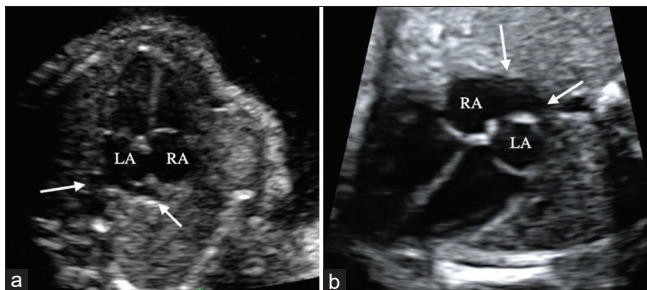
Two-dimensional gray-scale ultrasound of four-chamber view in a typical fetal heart versus right atrial-type total anomalous pulmonary venous return (right atrium [RA]-type total anomalous pulmonary venous return [TAPVR]). (a) Normal four-chamber view in a fetus at 23 weeks of gestation: Normal entry of the pulmonary veins to the left atrium (arrows), (b) In right atrial-type TAPVR at 24 weeks of gestation, the pulmonary veins connect to the RA (arrows). LA: Left atrium, RA: Right atrium
